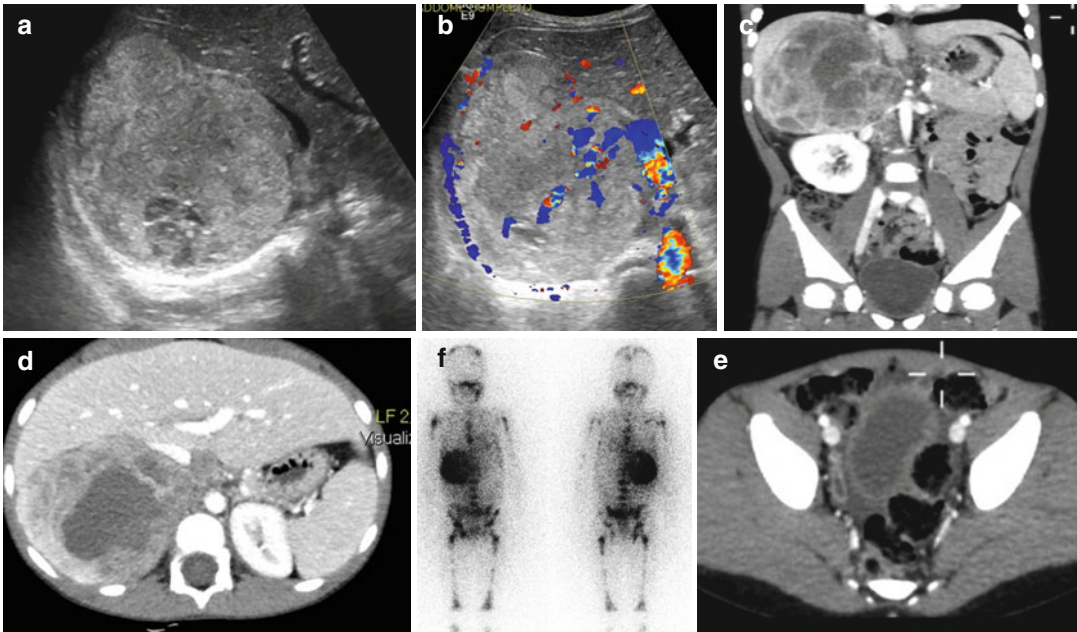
Male, 7 years old. The child went in emergency department with a palpable mass and pain at right abdominal quadrants. Right adrenal gland neuroblastoma was discovered. US (a, b): a heterogeneously echogenic hypervascular right adrenal mass with hypoechoic area inside was depicted. CT (c, MPR coronal reconstruction and d): it shows a large
